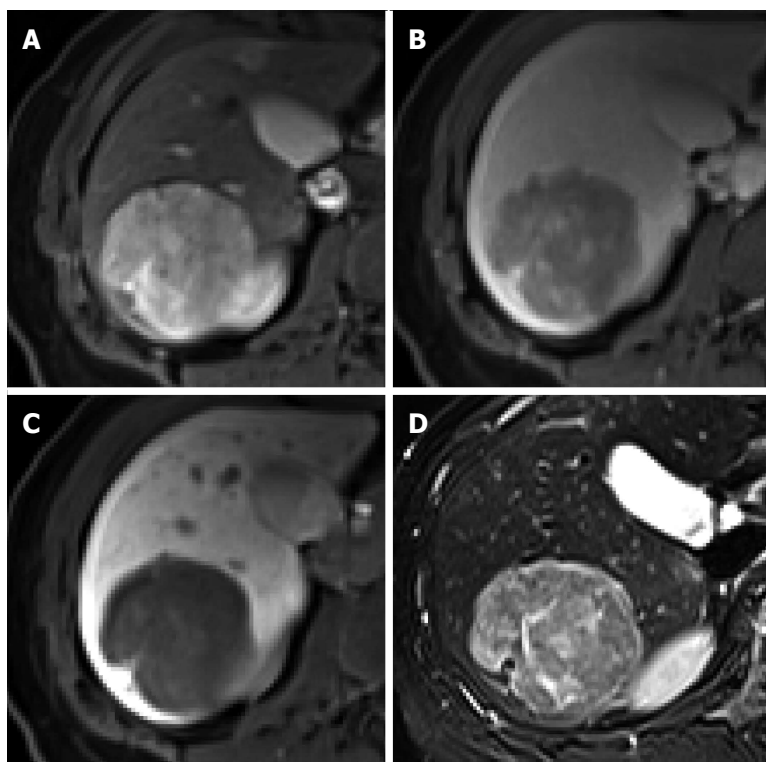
Hepatocellular adenoma in a 45-year-old woman. A: Hepatic arterial phase using gadoxetic acid shows moderate arterial enhancement; B: Transitional phase shows delayed washout without capsule or pseudocapsule; C: Hepatobiliary phase shows heterogeneous low signal intensity of the tumor; D: T2-weighted image shows a peripheral hyperintense band with moderate high signal intensity of residual tumor.
